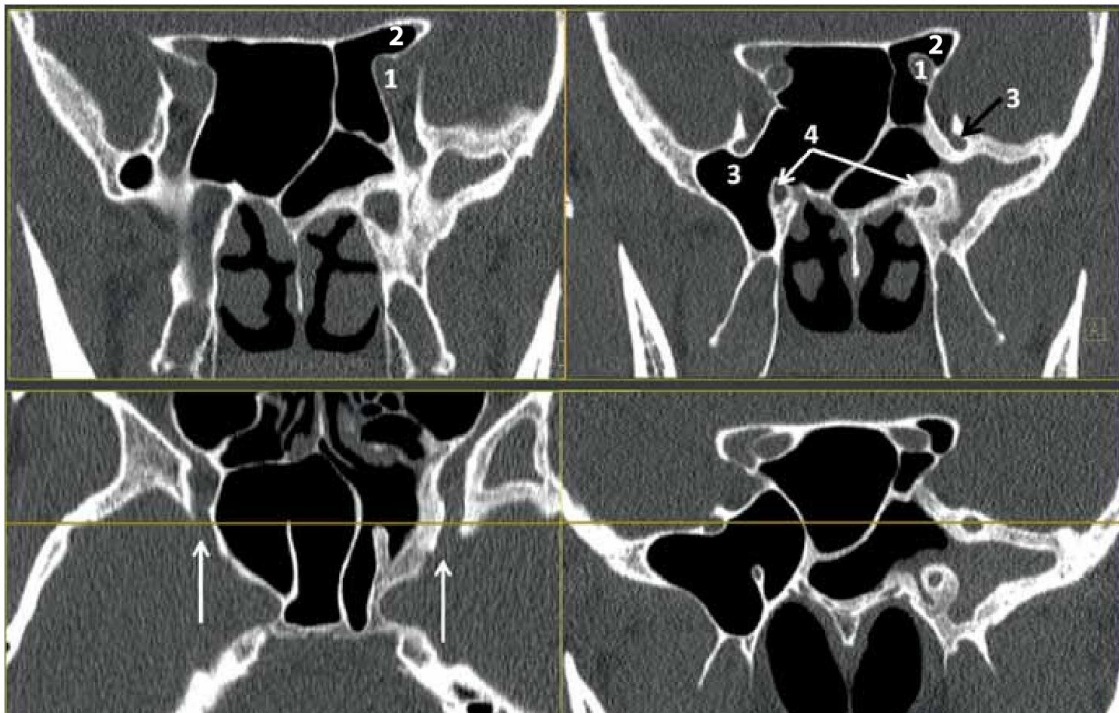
Complex sphenoid anatomy with extensive pneumatisation. Clockwise: 1 = (bulge of) optic nerve, 2 = pneumatized clinoid process. Please note, that in contrast to an optico-carotid recess, here pneumatisation towards the anterior clinoid goes superior to the optic nerve, 3 = foramen rotundum, 4 = Pterygoid (Vidian) nerve. When the axial CT level is placed through the foramen rotundum bilaterally, the corresponding canals can be seen on either side (arrows). Note "crab eye" appearance of (Vidian) nerve in pterygoid canal. There is bone thickening following long standing chronic sphenoiditis on the left side.
